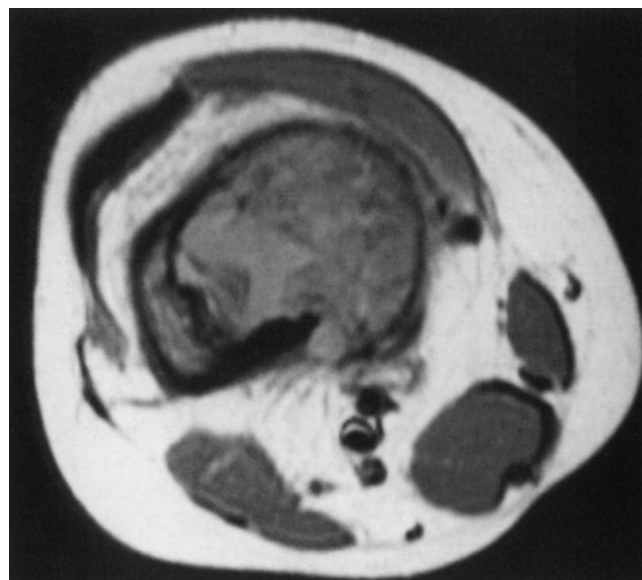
MRI which outlines the relationship of the tumor to the adjacent joints and blood vessels
